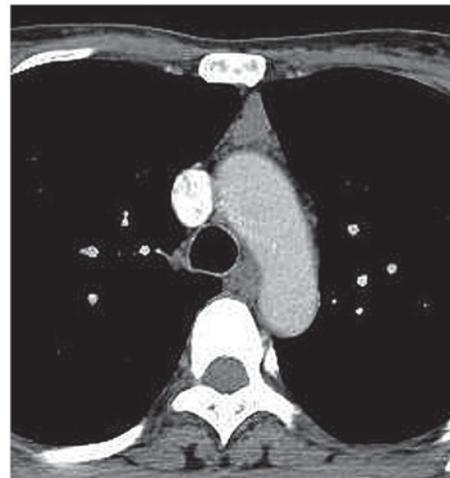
Contrast-enhanced computed tomography image of a female myasthenia gravis patient (age, 50 years) with lymphoid follicular hyperplasia. The thymus is triangular in shape and can be easily distinguished from adjacent tissue, particularly adipose tissue.
